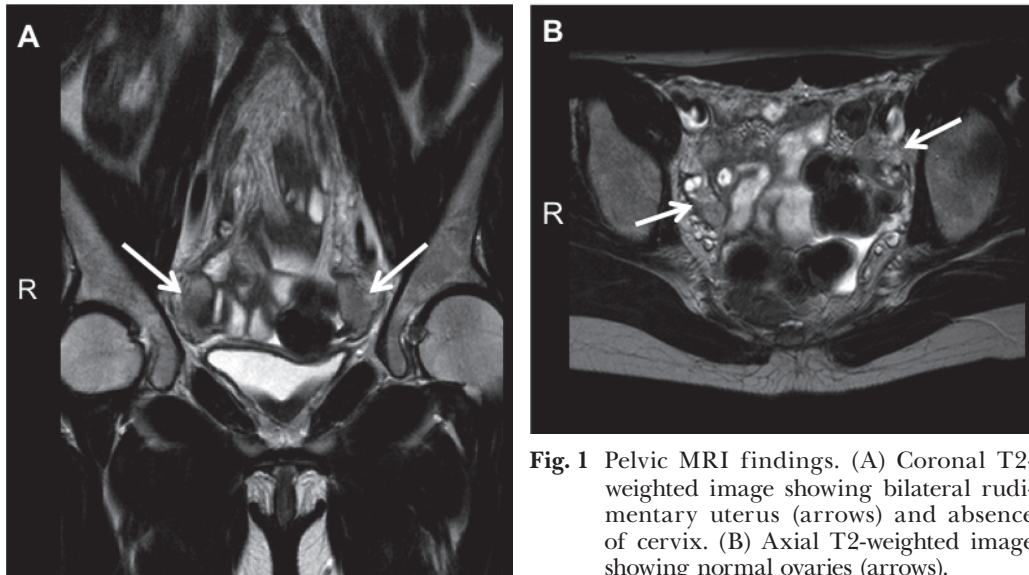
Pelvic MRI findings. (A) Coronal T2-weighted image showing bilateral rudimentary uterus (arrows) and absence of cervix. (B) Axial T2-weighted image showing normal ovaries (arrows).
